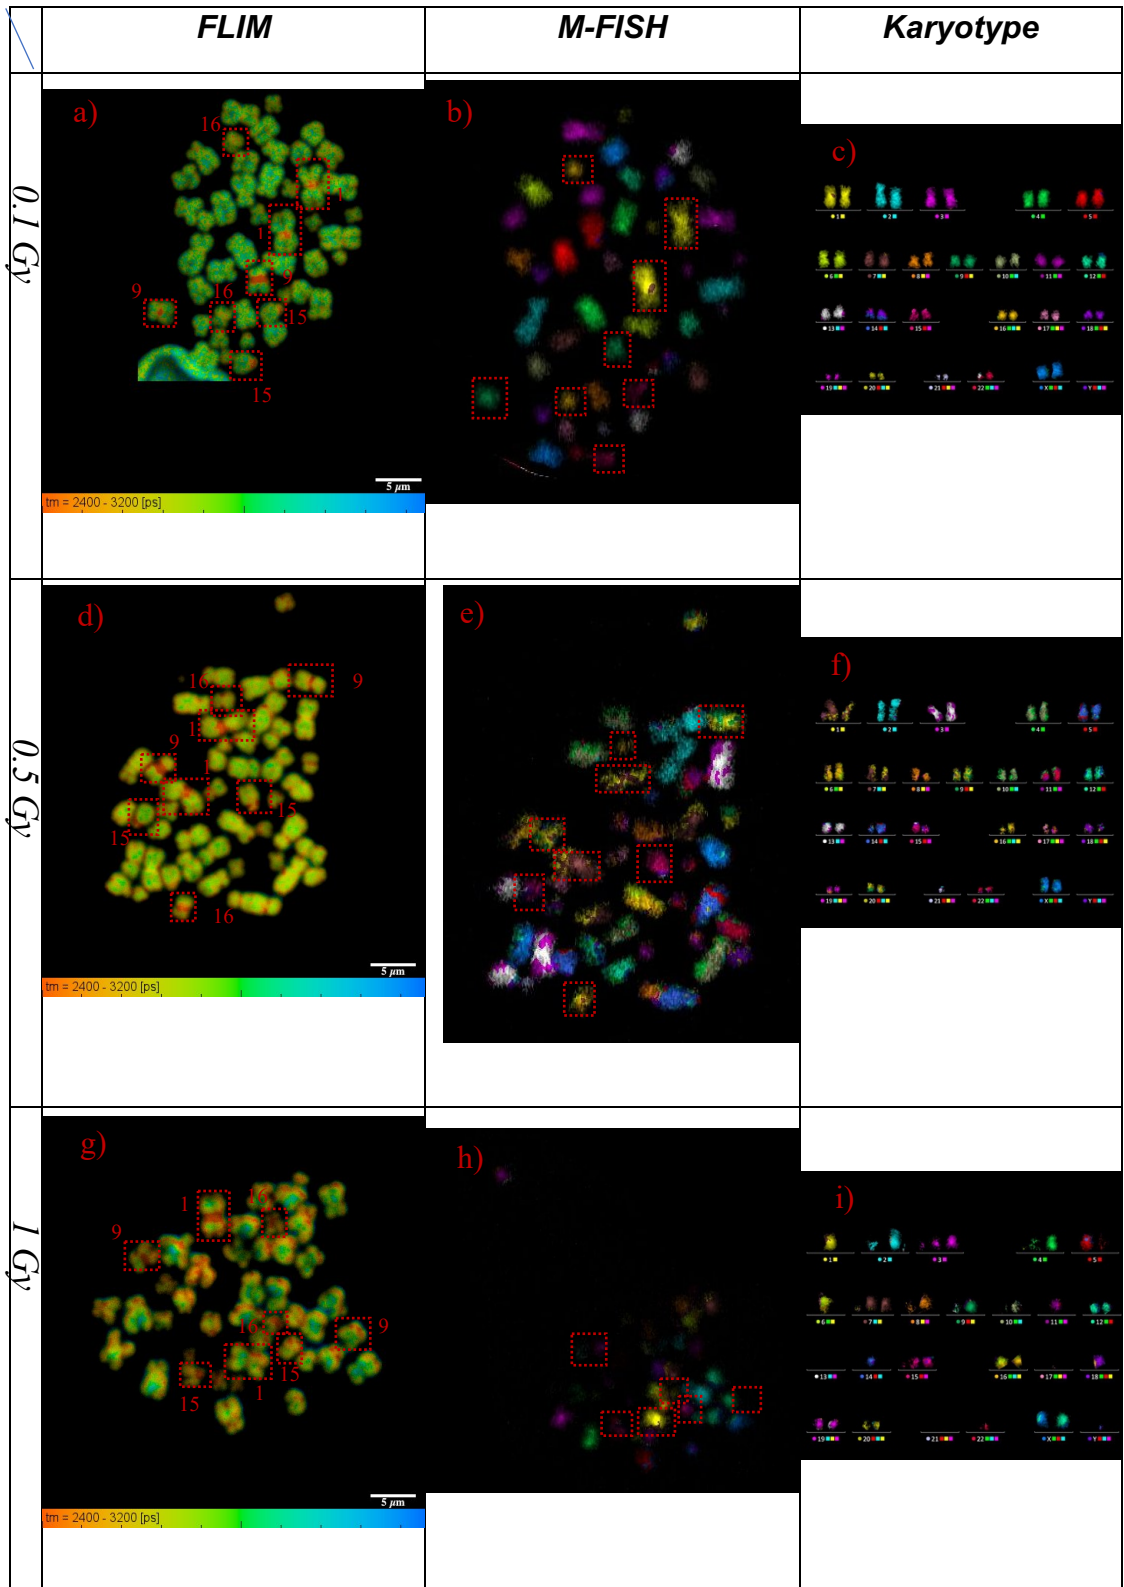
X-ray irradiated chromosomes spreads from a three different radiation doses and the spreads shown are imaged using FLIM and M-FISH, followed by karyotypes. The rows defines the three X-ray radiation doses and column defines the imaging techniques and the karyotype. Figure a), d) and g) are the FLIM images, b), e) and h) are the M-FISH images of the same spread, respectively, and c), f) and i) are the karyotype of the same spread obtained from the respective M-FISH spread. Red boxes denotes homologous heteromorphous chromosomes with a short lifetime at their heterochromatin region in all three independent spreads. A map of DAPI lifetime ranged between 2.4 ns to 3.2 ns, and scale bar= 5 μ m. Objectives used for FLIM imaging is 60x water and for M-FISH is 63x immersion oil.
